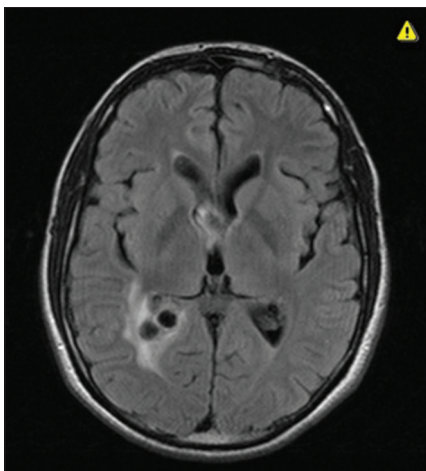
T1-weighted showing lesion in right lateral ventricle
